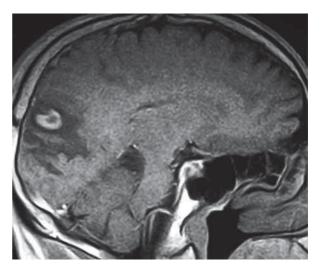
Sagittal magnetic resonance imaging (MRI) revealed a tumour localized in the left parietal lobe
